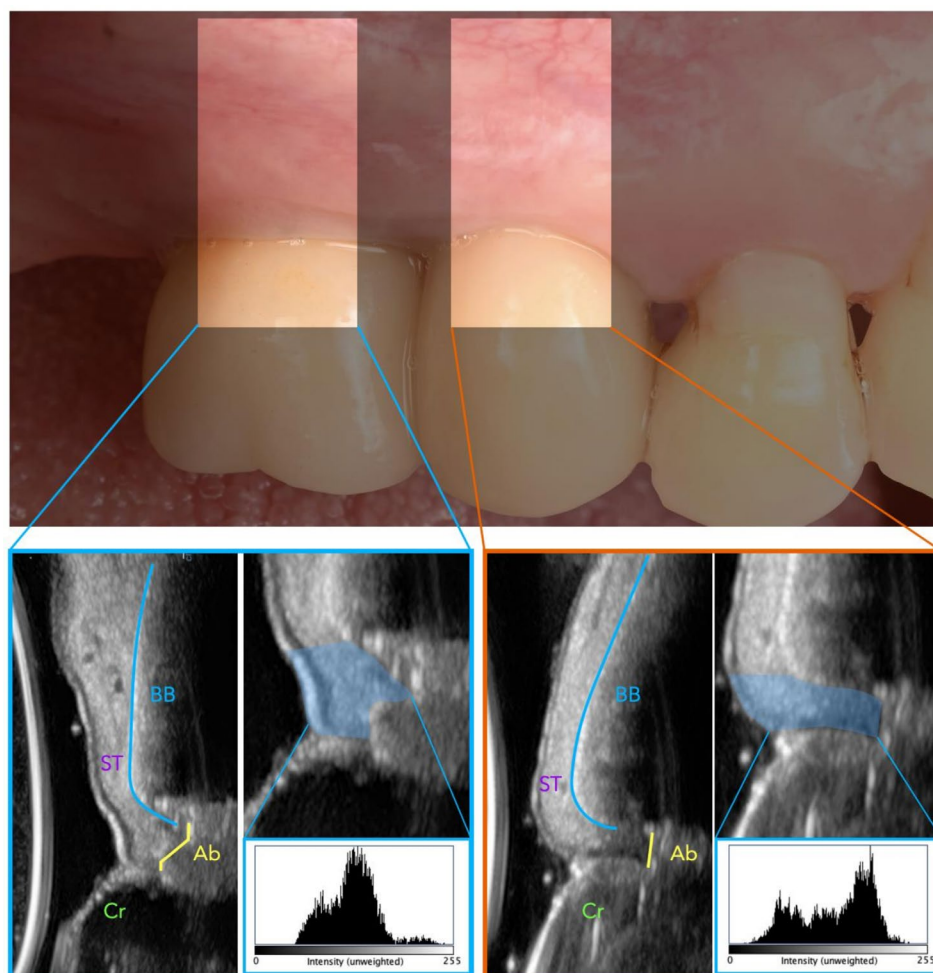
High-frequency ultrasonographic examination and echo-intensity analysis of the supracrestal soft tissue compartment. “Cr” identifies the implant-supported crown, “Ab” the abutment, “ST” the soft tissue, and “BB” the buccal bone.
